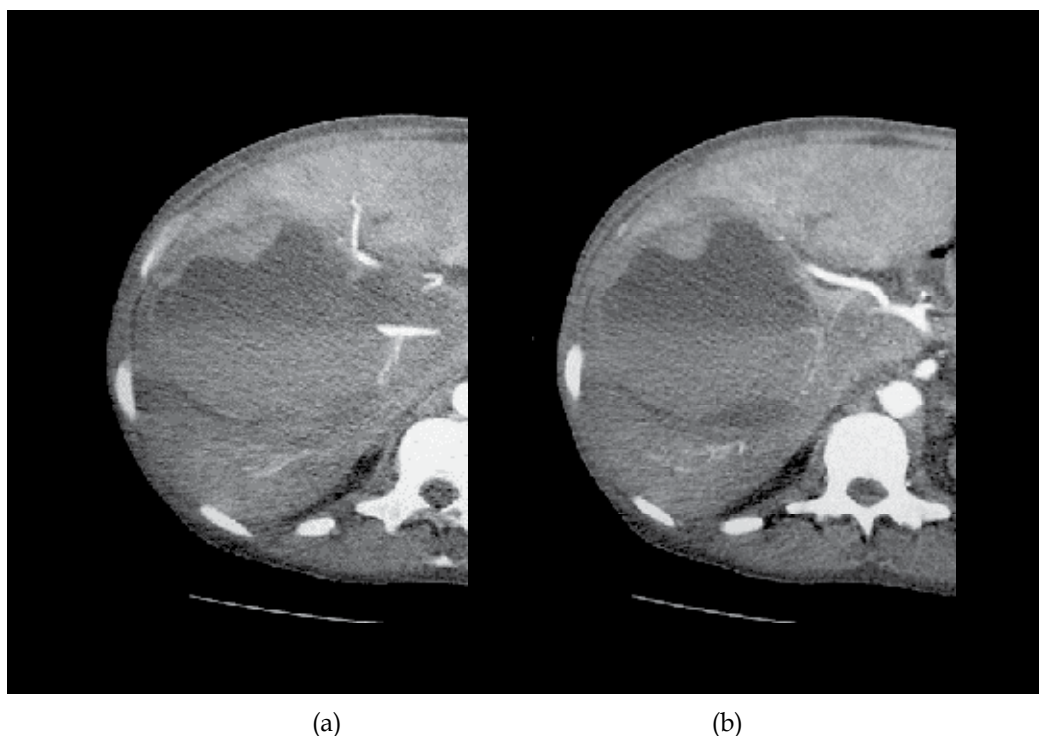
(a & b) CT scans on a patient with a past history of a percutaneous liver biopsy showing a ruptured pseudoaneurysm with active bleeding.
